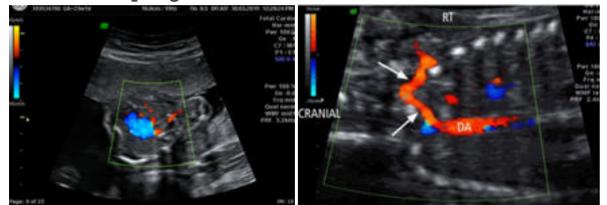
Doppler examination showing aberrant right subclavian artery arising separately from aorta.
